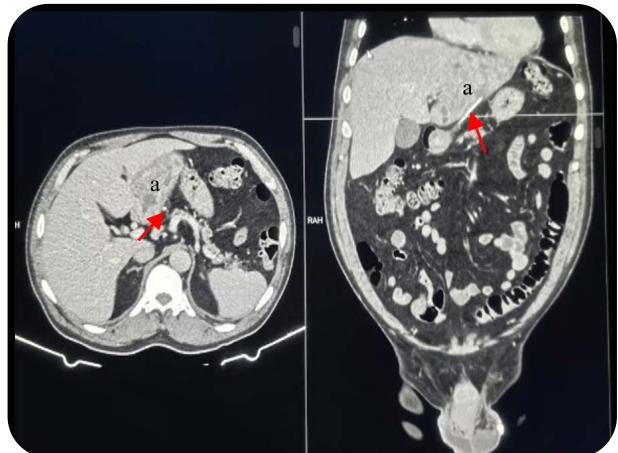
Axial cut, coronal, abdominal CT. (a) abscessed collection which involves hepatic S2-3; (red arrow) foreign body
